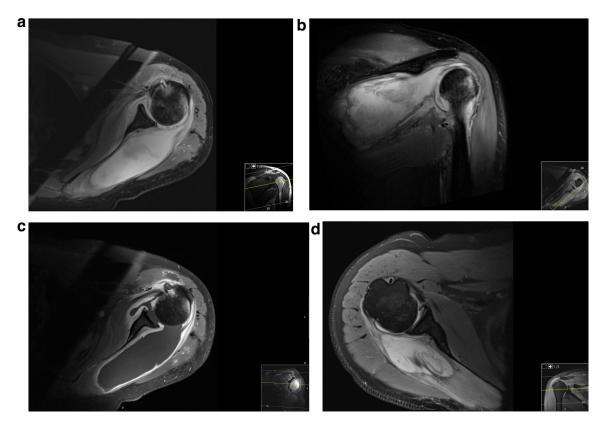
Axial (A), coronal (B) fat-saturated PD and axialpost-contrast fat-saturated T1-weighted (C) MRI performed 12 days after admission to our hospital shows a large left shoulder rotator cuff collection communicating with the glenohumeral joint, which is distended with fluid and demonstrates capsule hyperenhancement compatible with synovitis. Axial fat-saturated PD MRI of the right shoulder (D) demonstrates similar but less pronounced findings on the left shoulder.
